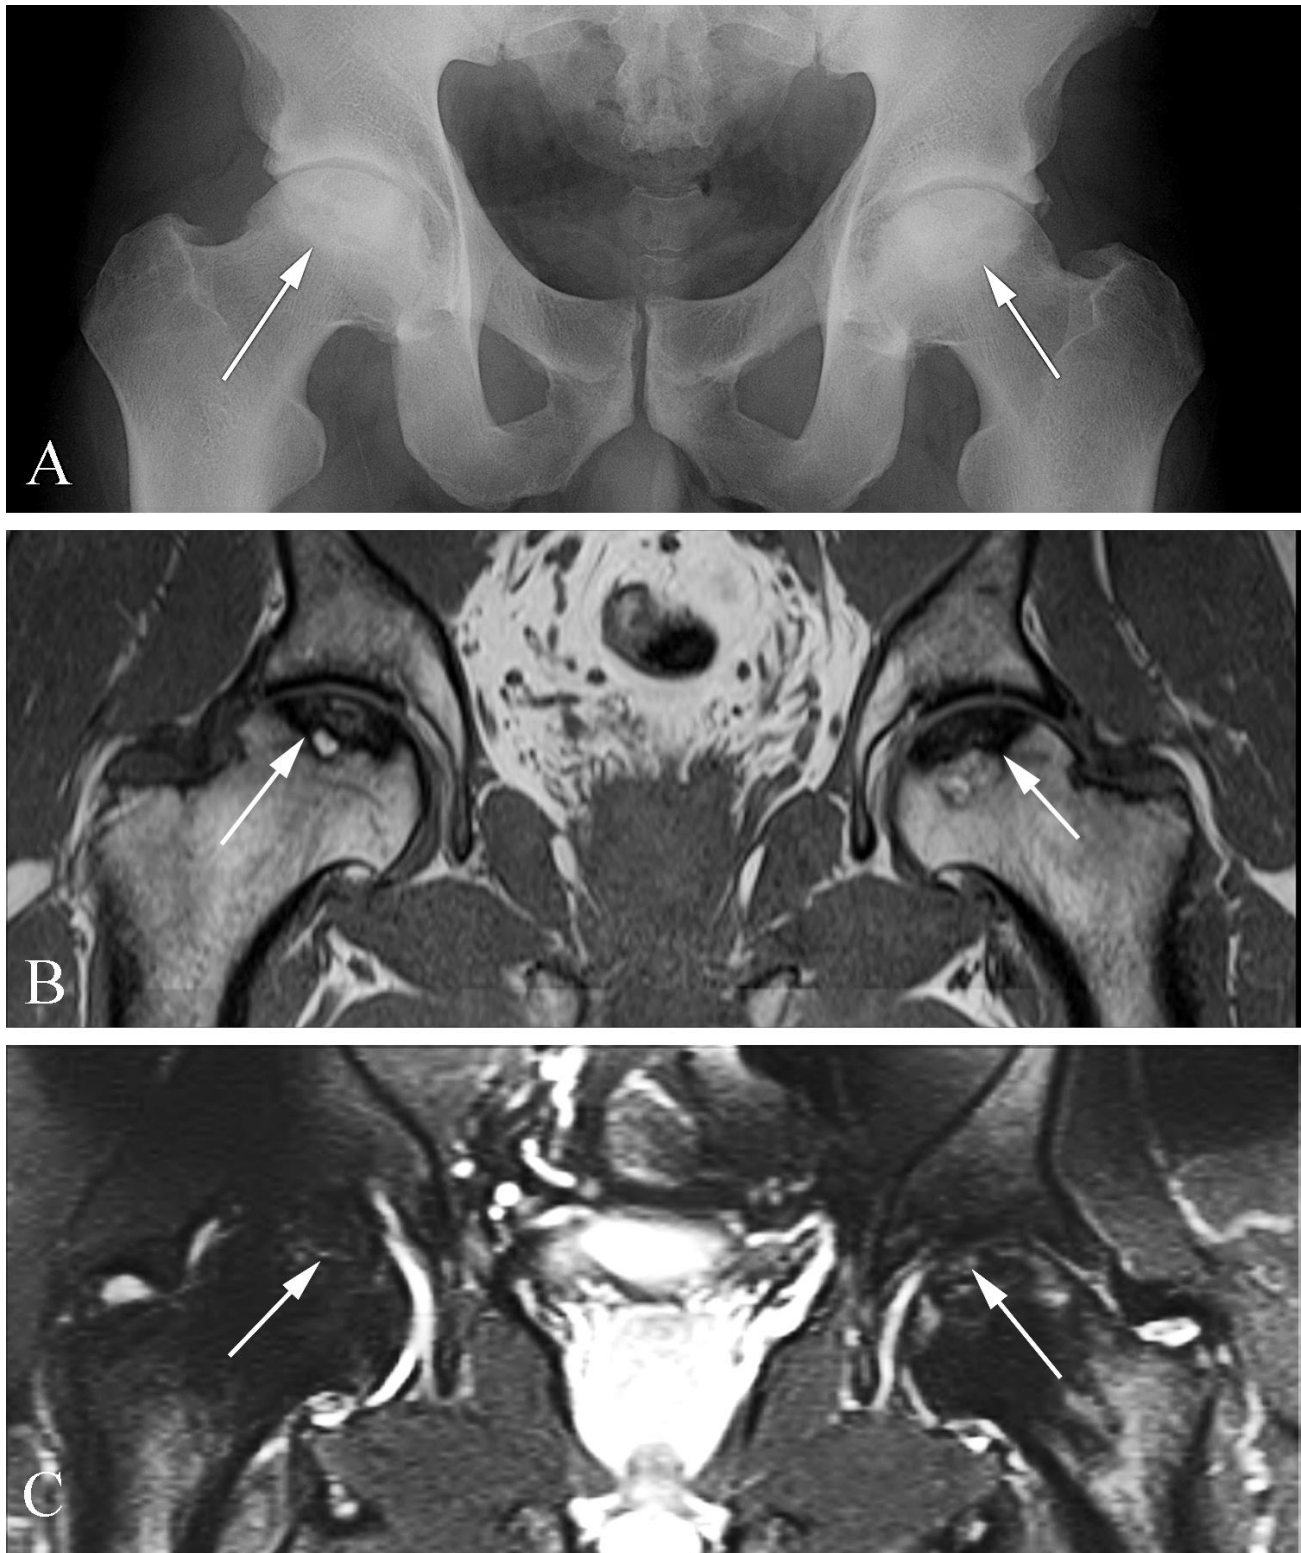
Avascular necrosis of the hips in a 38 year old man with chronic hip pain. A. AP view of the pelvis shows abnormal increased density (arrows) in both femoral heads. B. Coronal T1 weighted MR image demonstrates extensive decreased signal intensity (arrows) in the subchondral aspects of both femoral heads. Note mixed signal intensity at the interface between the normal signal intensity in the femoral necks and the decreased signal intensity in the heads. C. Coronal STIR image demonstrates mixed signal intensity in the femoral heads (arrows).
